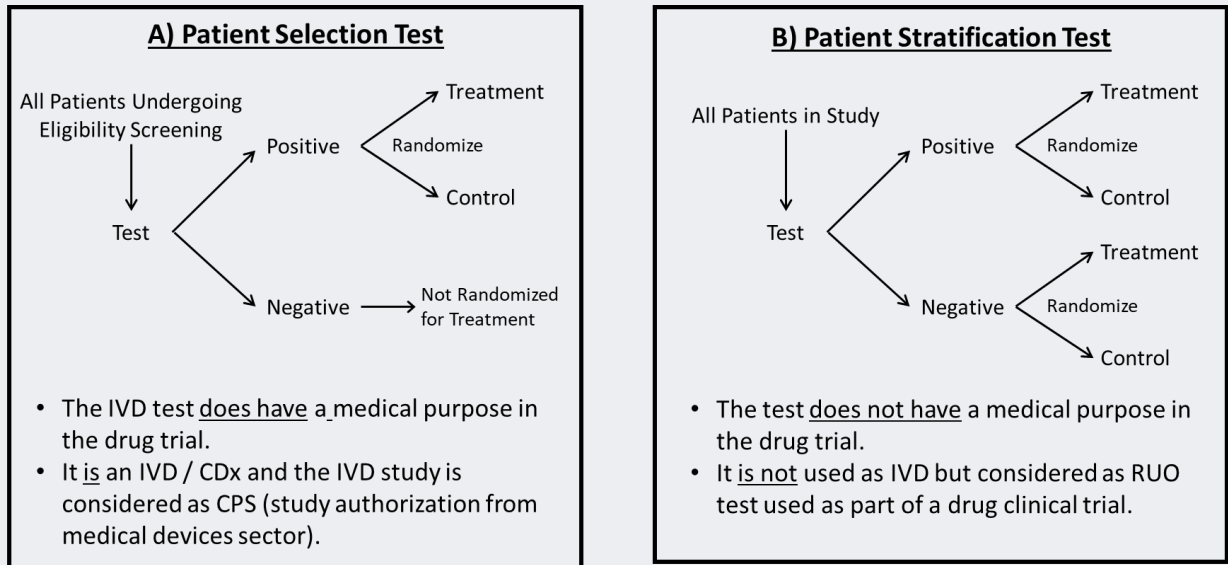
Clinical trial design - CTA use for patient selection (A)) versus CTA use for patient stratification (B)).
